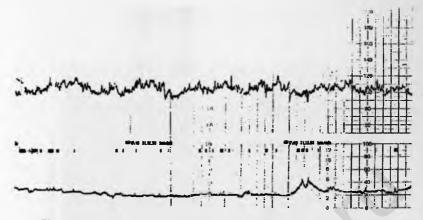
CTG of dead baby - ultrasound with fetal movement profile.
